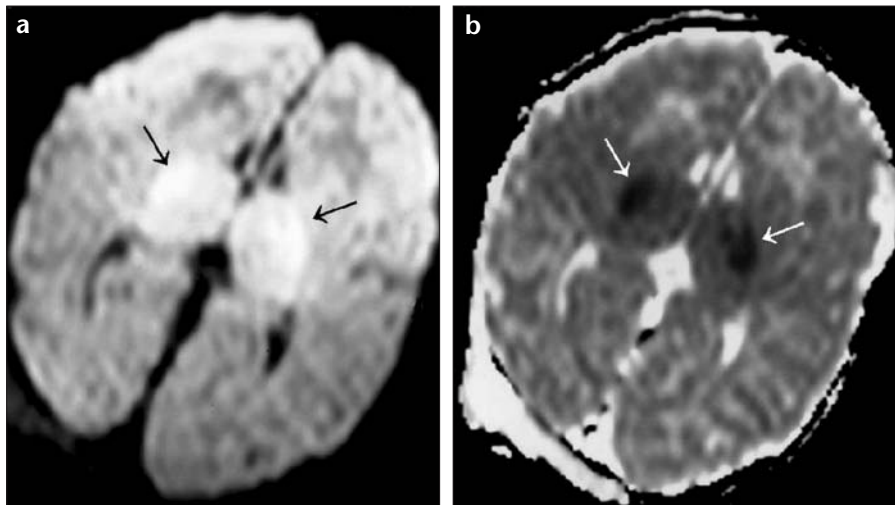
a, b. Stage I hypoxic ischemic encephalopathy. Diffusion restriction representing acute ischemia is seen on DWI (diffusion-weighted imaging) obtained in the first 24 h. Diffusion-weighted image (b: 1000 s/mm²) (a) shows increased signal intensity at the bilateral thalami, posterior limbs of the internal capsules, and the globi pallidi (black arrows); however, on ADC (apparent diffusion coefficient) map (b), these areas are represented as signal loss (white arrows).
